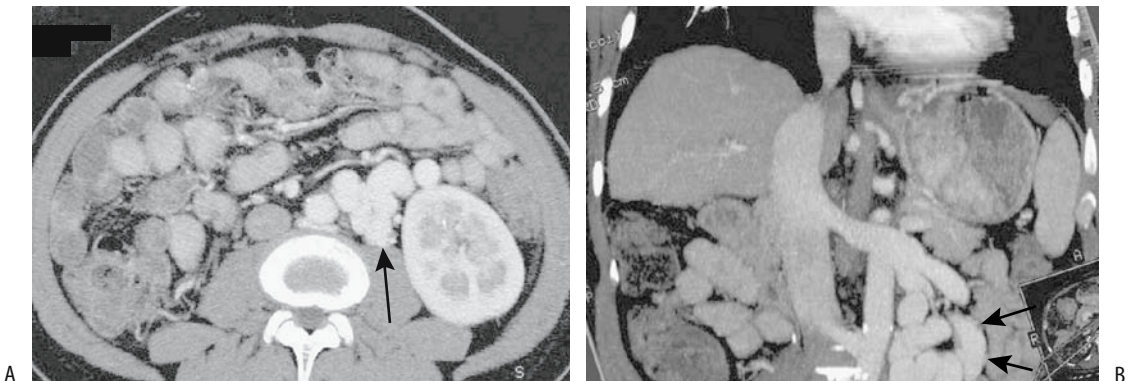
Retroperitoneal shunt. A: Postcontrast CT shows tortuous, dilated vessels adjacent to left kidney (arrows). B: Coronal maximum intensity projection CT portal venography detects a tortuous shunt (arrows) communicating with left renal vein. (Source: Kang HK, Jeong YY, Choi JH, et al. Three-D multi-detector row ct portal venography in evaluation of portosystemic collateral vessels in liver cirrhosis. *RadioGraphics* 2002;22:1053–1061, with permission from the Radiological Society of North America.)
